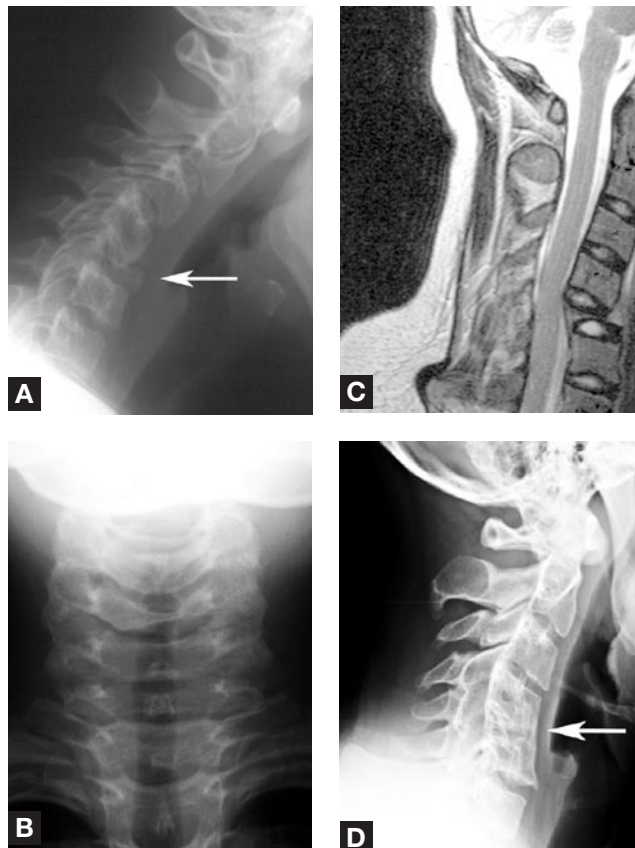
(A) Lateral plain radiograph of the cervical spine of patient 1 prior to biopsy. There is near complete collapse of the vertebral body of C5 (arrow) and anterior angulation of the cervical spine above C5 leading to a 34° kyphosis. (B) Anteroposterior plain radiograph of the cervical spine of patient 1 prior to biopsy. (C) T₂-weighted sagittal magnetic resonance image showing complete destruction of the vertebral body of C5 (arrow). (D) Lateral plain radiograph of the cervical spine taken 5 years after biopsy and revealing fusion of the vertebral bodies of C4 to C6 (arrow) and a 20° kyphosis.
